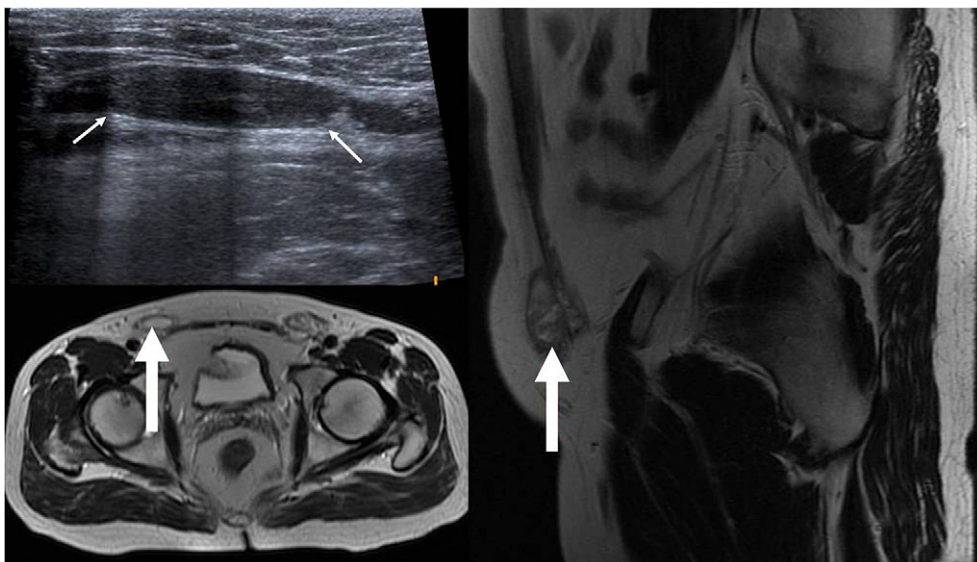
Ultrasound showing an undescended testis in the right inguinal canal (small arrows). The diagnosis was confirmed on axial and sagittal T2-weighted MRI (large arrows).
